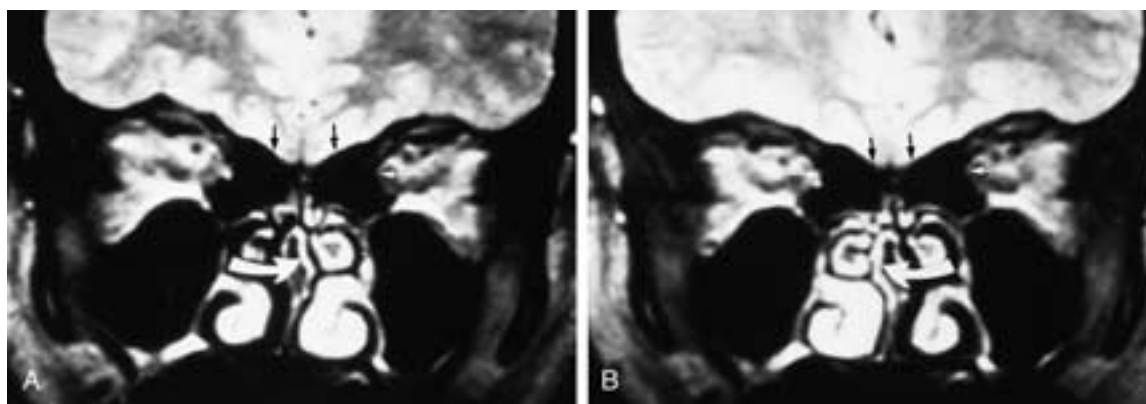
Nasal cycle on MR imaging. A and B, Coronal T2-weighted MR images of the anterior ethmoid sinuses show the changing edema of the nasal cavity (*curved arrow*), the ethmoid sinus mucosa, and the changing size of the turbinates. Note the lack of signal for definition of the ethmoid sinus roof and lamina papyracea (*arrows*).
